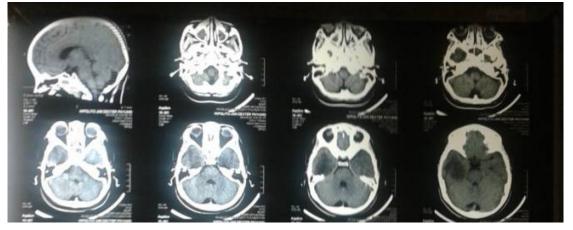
Plain cranial CT images of our 5-year old patient showing a non enhancing lesion over the right temporo-parietal area as identified by the red arrows.
